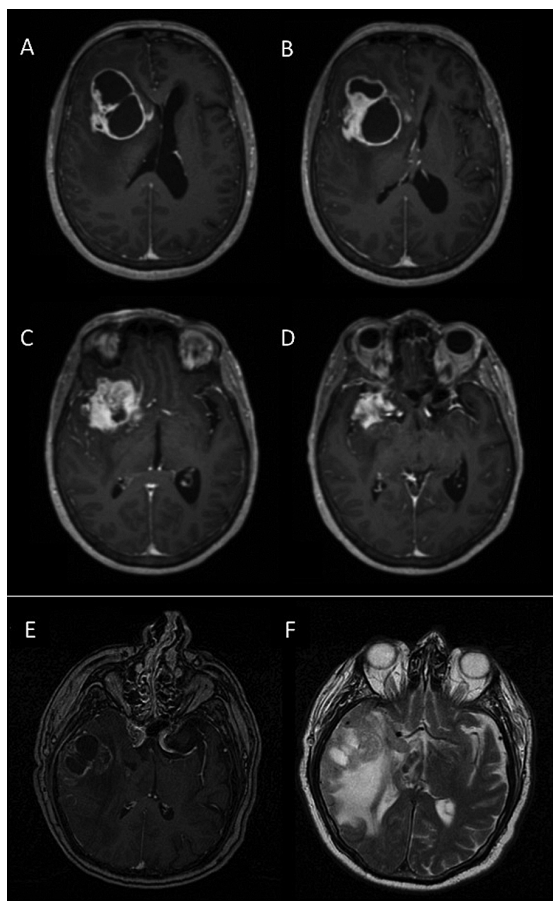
Magnetic resonance imaging of anaplastic ganglioglioma. A, B, C, D: Axial postcontrast T1-weighted MRI showing a right frontoinsular cystic anaplastic ganglioglioma surrounded with annular and homogeneous contrast enhancement but with a diffuse pattern of infiltration toward basal ganglia. The tumor creates a mass effect on the ventricles. E: Axial postcontrast T1-weighted MRI showing a right temporal anaplastic ganglioglioma with heterogeneous contrast enhancement, central necrosis, and peripheral edema. F: Axial T2-weighted MRI of the same tumor showing peripheral edema in hypersignal and showing herniation of the temporal uncus on the right cerebral peduncle.
